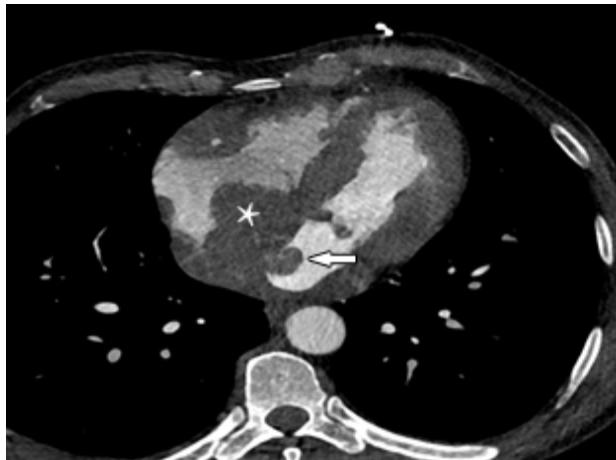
Contrast-enhanced cardiac CT demonstrating a broad-based right atrial mass infiltrating the interatrial septum, along with a smaller mass within the left atrium.
